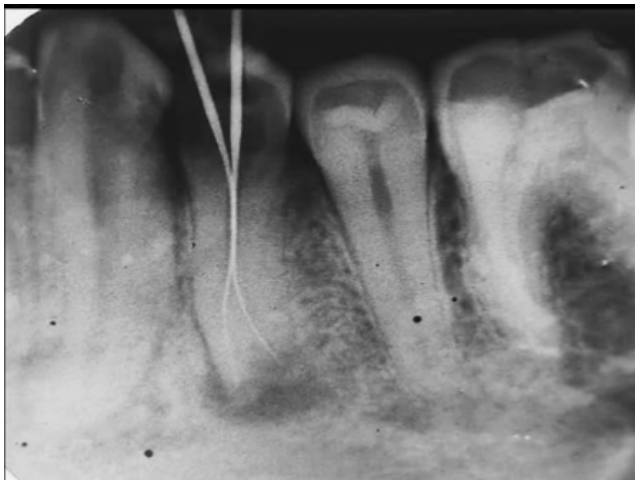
Radiograph of mandibular right 1st premolar (Working length)
